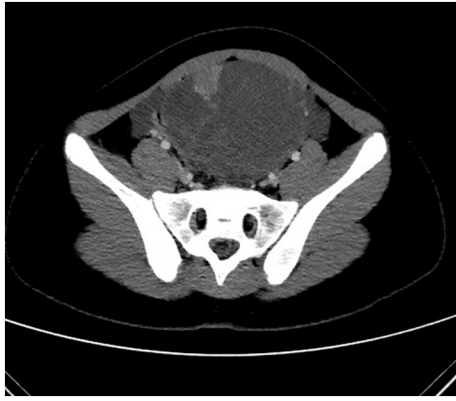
Computed tomography (CT) scan abdominopelvic region showing heterogeneous hemorrhagic cystic and solid mass.
